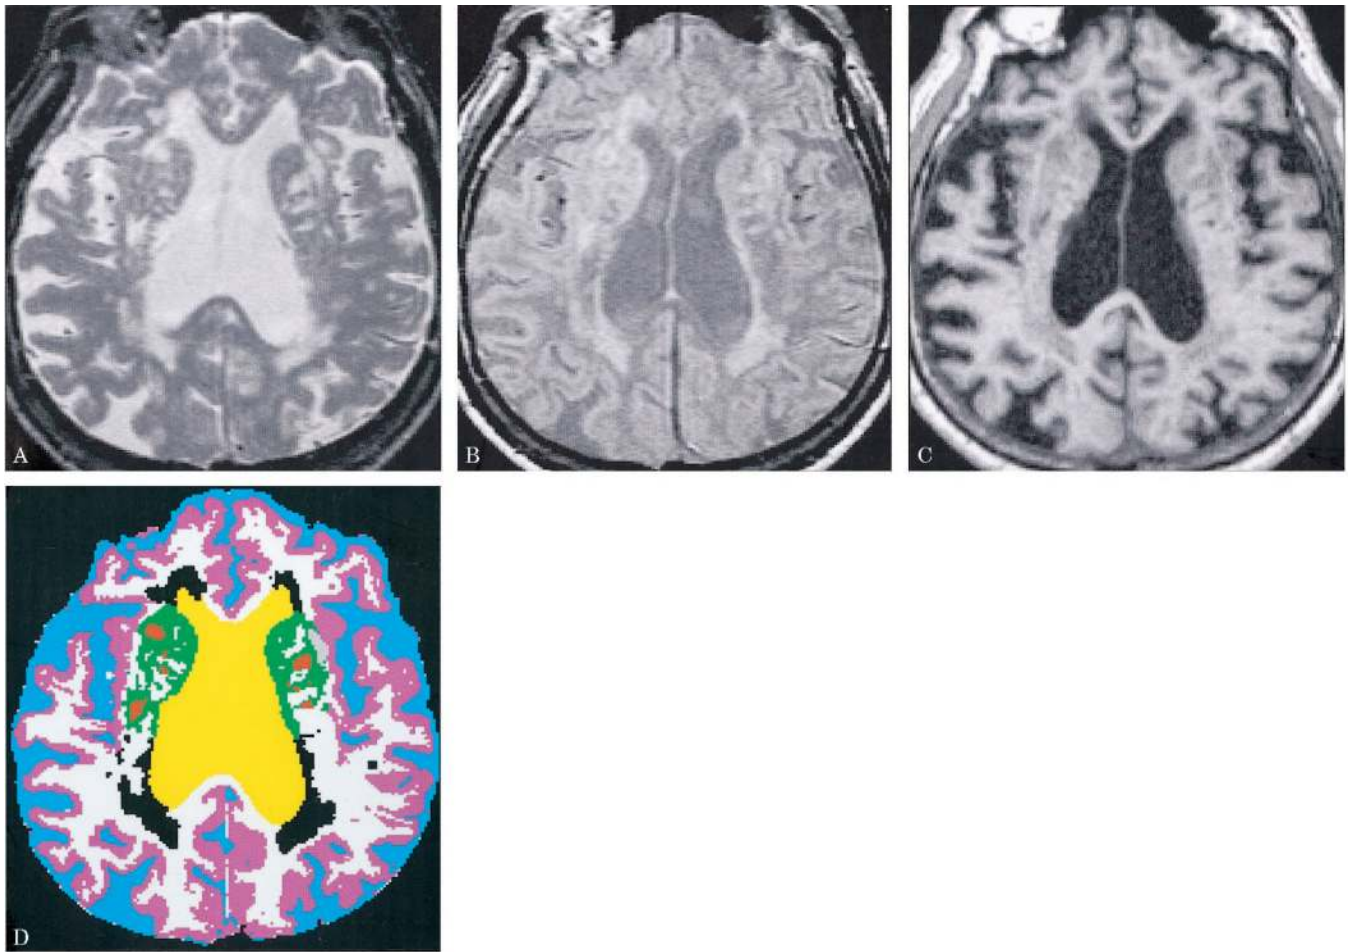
MR (A, T2-weighted; B, proton density-weighted; C, T1-weighted) and segmented (D) images are presented for the midventricular axial slice of an 86-year-old man with dementia and lacunes. The segmented image (D) displays sulcal CSF in blue, ventricular CSF in yellow, cortical gray matter in pink, subcortical gray matter in green, white matter in white, white matter signal hyperintensities in black, and lacunes in red.
